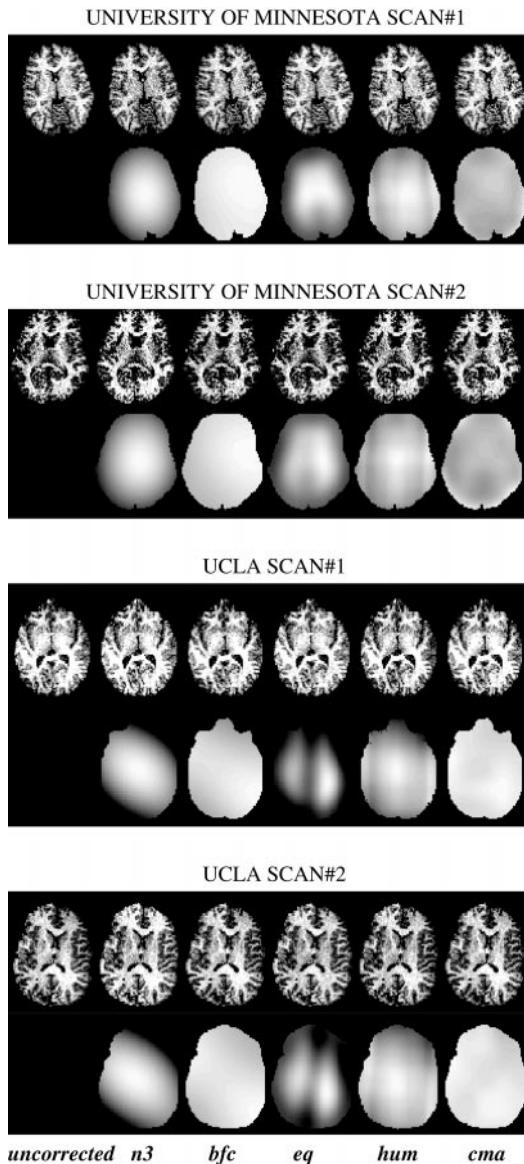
A representative slice from the uncorrected and corrected volumes (upper rows) and from the extracted bias volumes (lower rows) for each of the UMN and UCLA high-resolution MRI brain scans.
